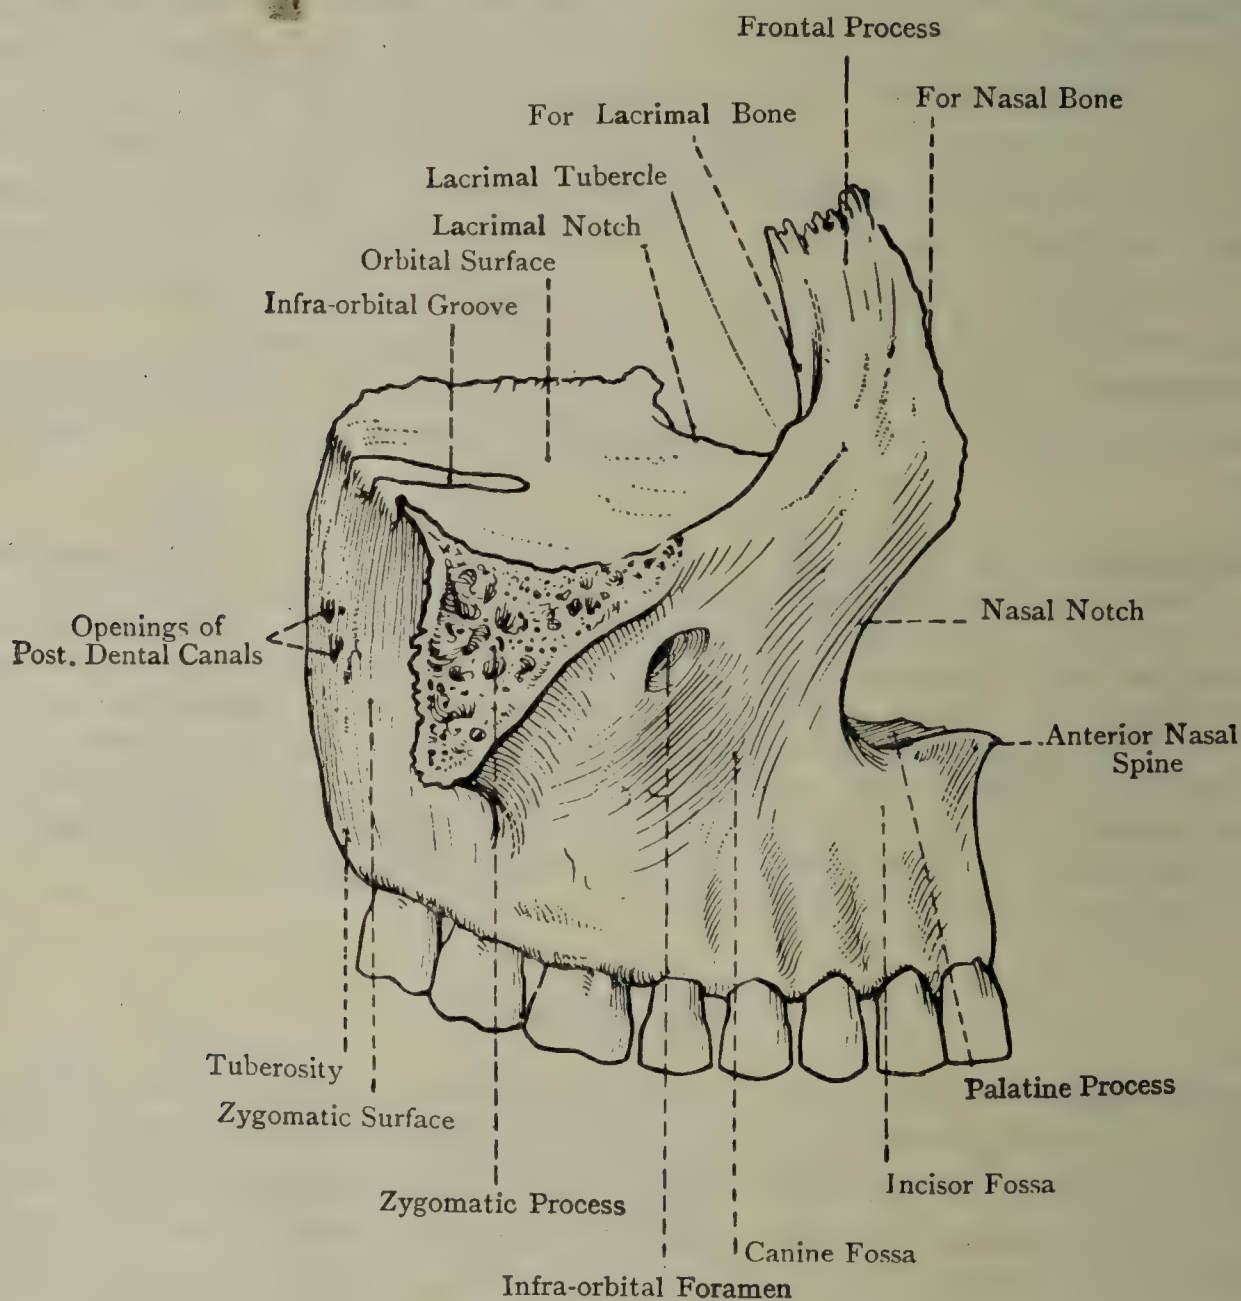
THE RIGHT MAXILLA (LATERAL ASPECT).
